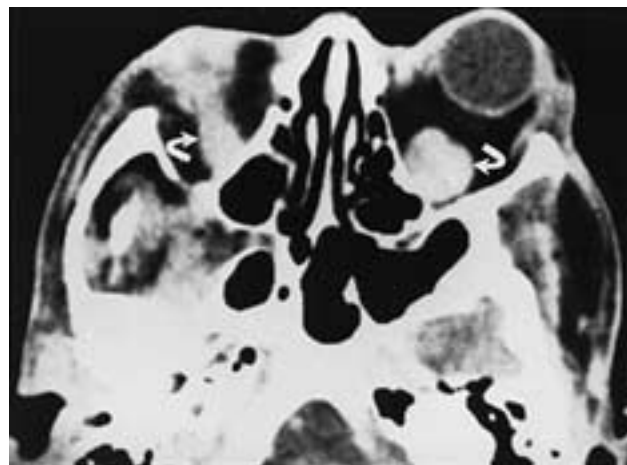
Thyroid myopathy. Axial CT scan shows enlargement of the inferior rectus muscles (*arrows*).
